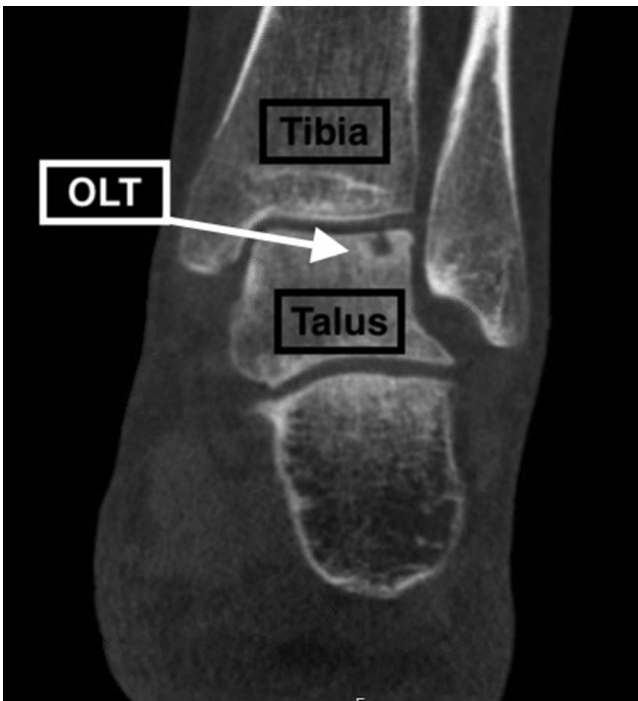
Coronal computed tomography scan view of left ankle showing osteochondral lesion of lateral talus (OLT).
